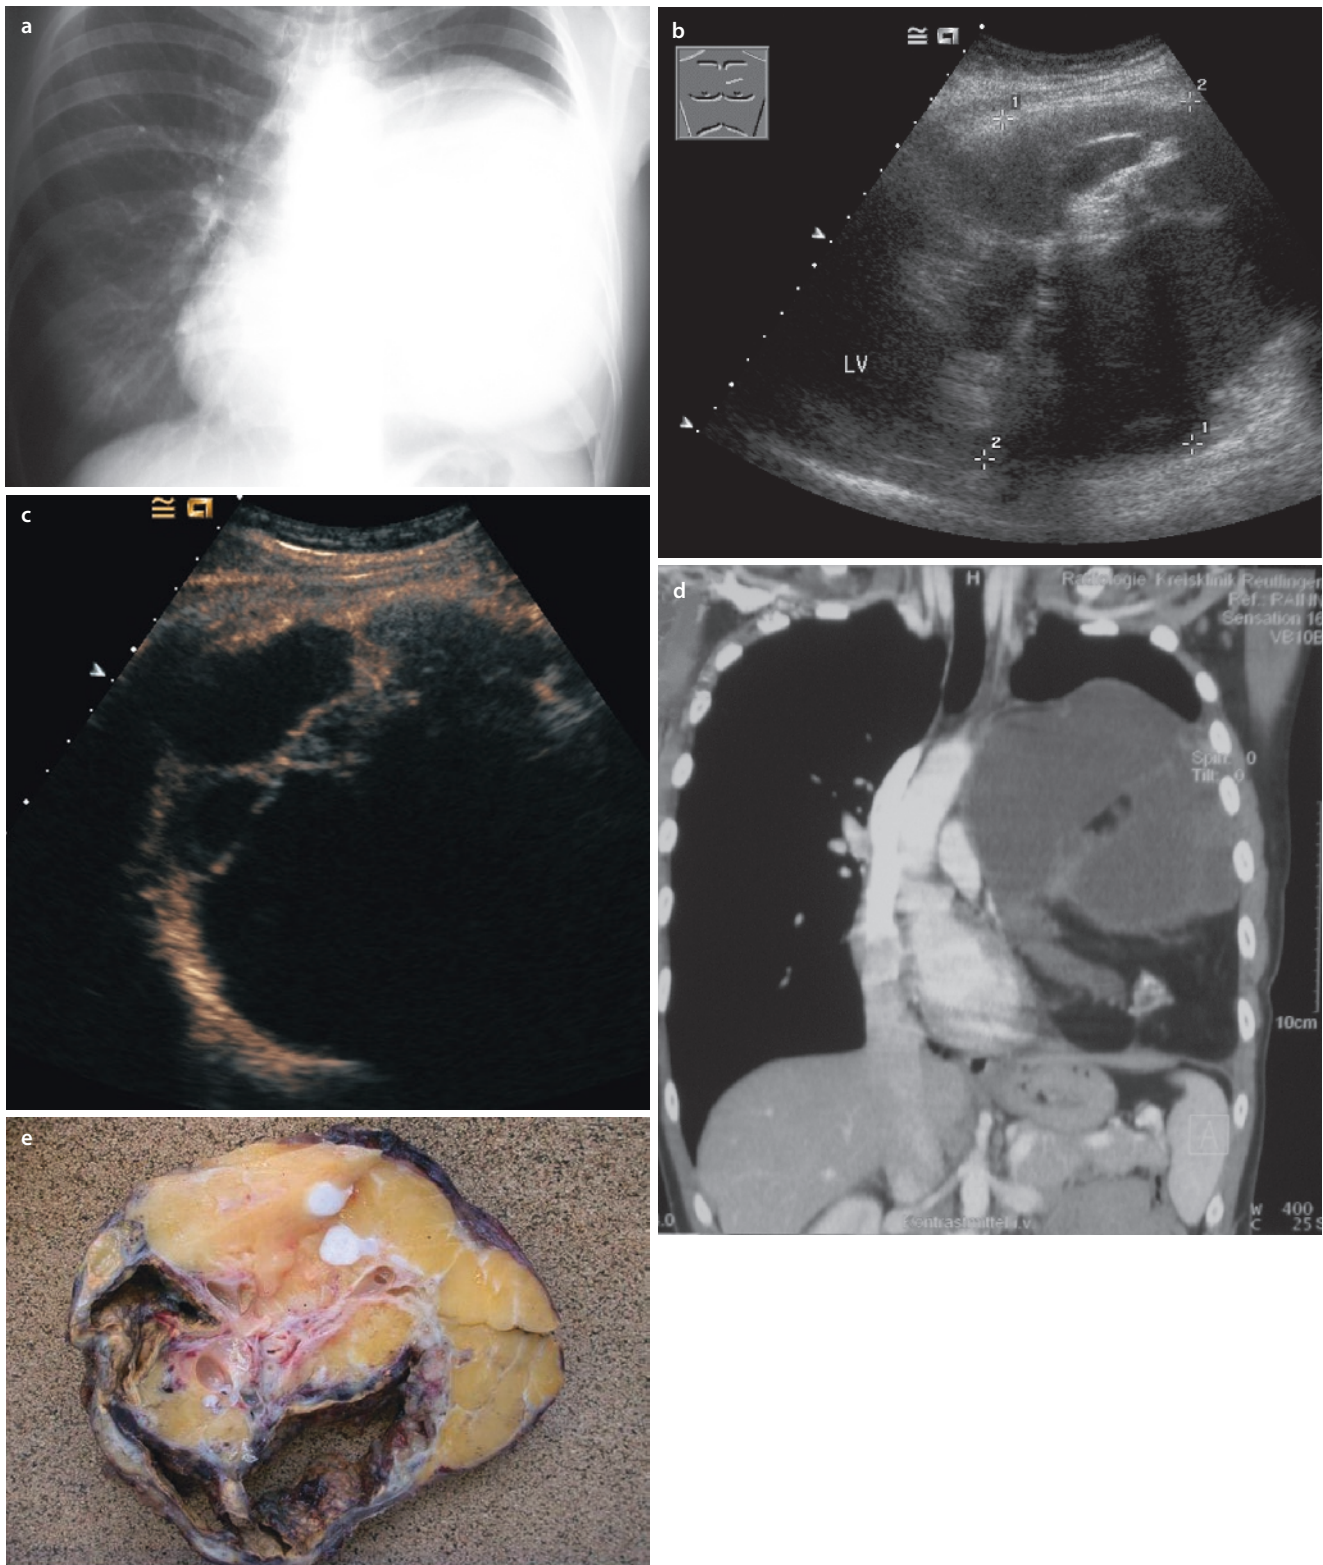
Cystic teratoma. A 32-year-old patient, slight dyspnea when jogging. a Plain chest radiograph with tumor and mediastinal distortion to the right. b Left parasternal section in supine position. Clearly delineated mass with echogenic septum-like structures. In the center, high amplitude reflexes with dorsal shadowing. The space-occupying lesion displaces the pleura to the side toward the thoracic wall, which moves with breathing. The feeding vessels suggest a mediastinal origin of the lesion. c Contrast-enhanced sonography
